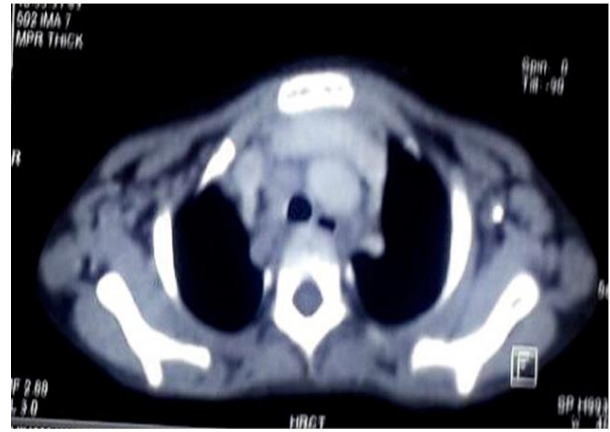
Contrast enhanced CT scan of thorax showing conglomerate, homogeneously enhancing mediastinal lymphadenopathy.
